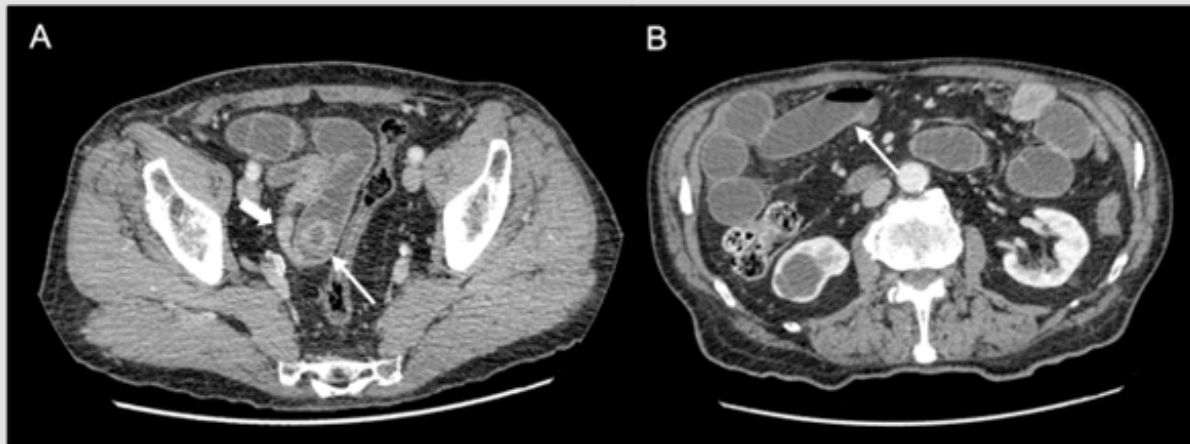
Contrast-enhanced CT shows a stone in the ileum (Fig. 2A, thin arrow) with collapsed small bowel loops distal to the stone (Figure 2A, thick arrow). The small bowel loops proximal to the stone are dilated with some air-fluid levels (Figure 2B, thin arrow).
